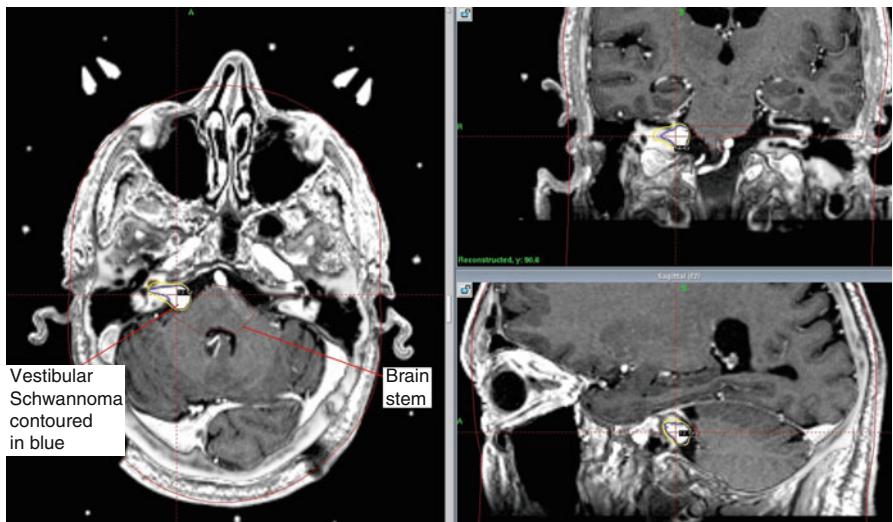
Vestibular schwannoma GTV outlined on CT/MRI fusion for SRS, typically gadolinium-enhanced T1-weighted MRI sequence is fused with contrast-enhanced planning CT scan
